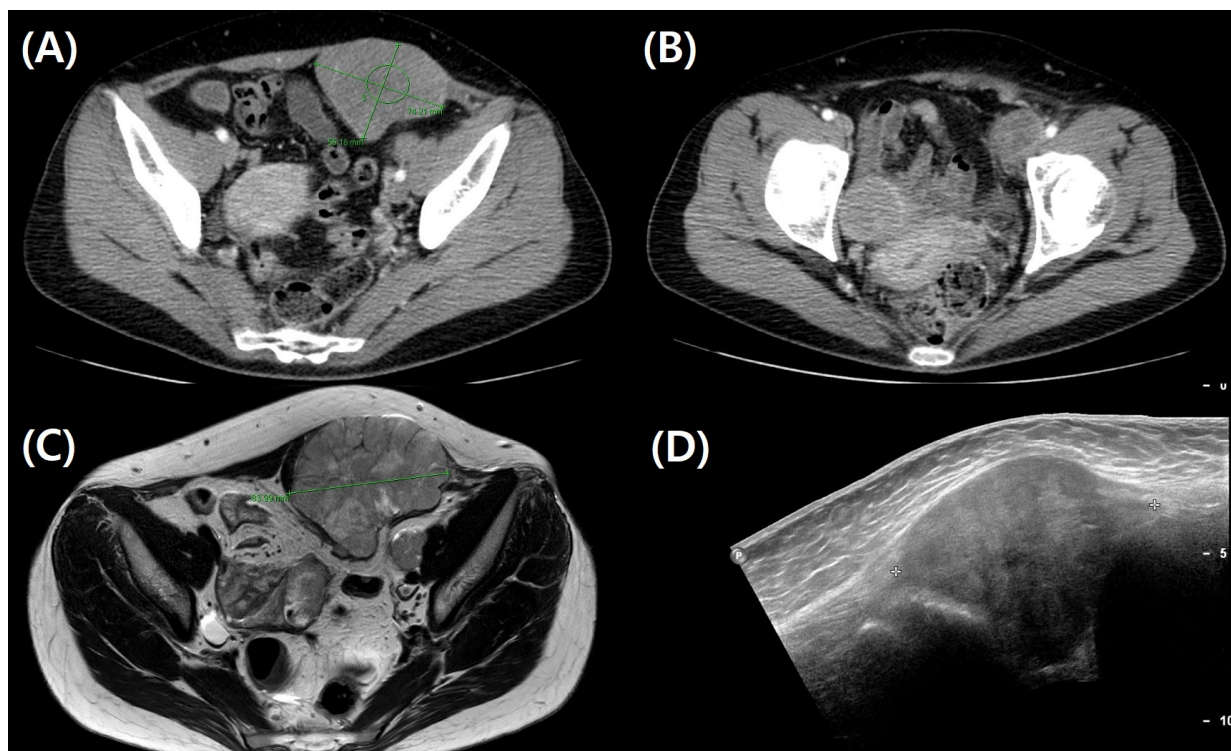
(A) Abdomino-pelvic computed tomography (CT) shows a mass originating from the left lower abdominal wall that is measured 7.4×5.5 cm in diameter. This location corresponds to the site of trocar insertion in the previous laparoscopic surgery; (B) Abdomino-pelvic CT shows no specific findings in the right ovary; (C) Abdomino-pelvic magnetic resonance imaging (MRI) showing the mass in the abdominal wall; (D) Transabdominal ultrasound imaging of the mass in the abdominal wall taken during the needle biopsy.
